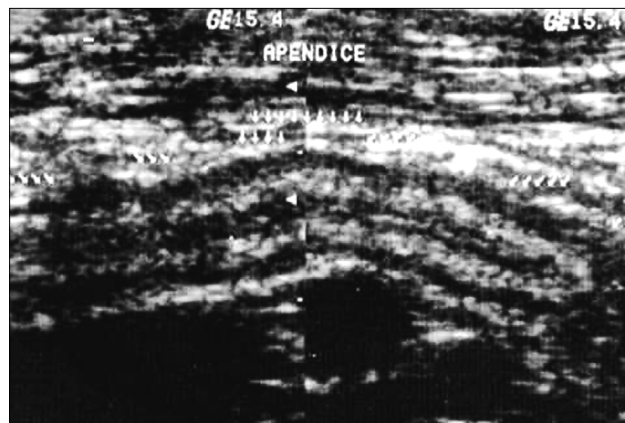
Ultrasonography. Appendix with thickened walls (4 mm) and loss of normal stratification.
